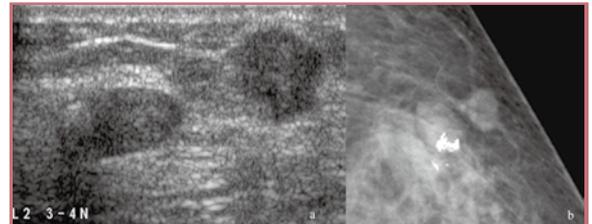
sonography of partially calcified fibroadenoma (left) and adjacent invasive ductal carcinoma (right) b, same masses on mammogram
